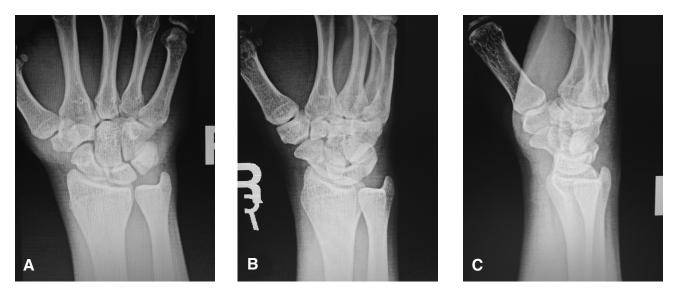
Plain radiographs of the injured wrist. Standard PA (A), oblique (B), and lateral (C) views demonstrate no obvious bone fracture or dislocation. Specifically, there is no apparent fracture within the carpus.
